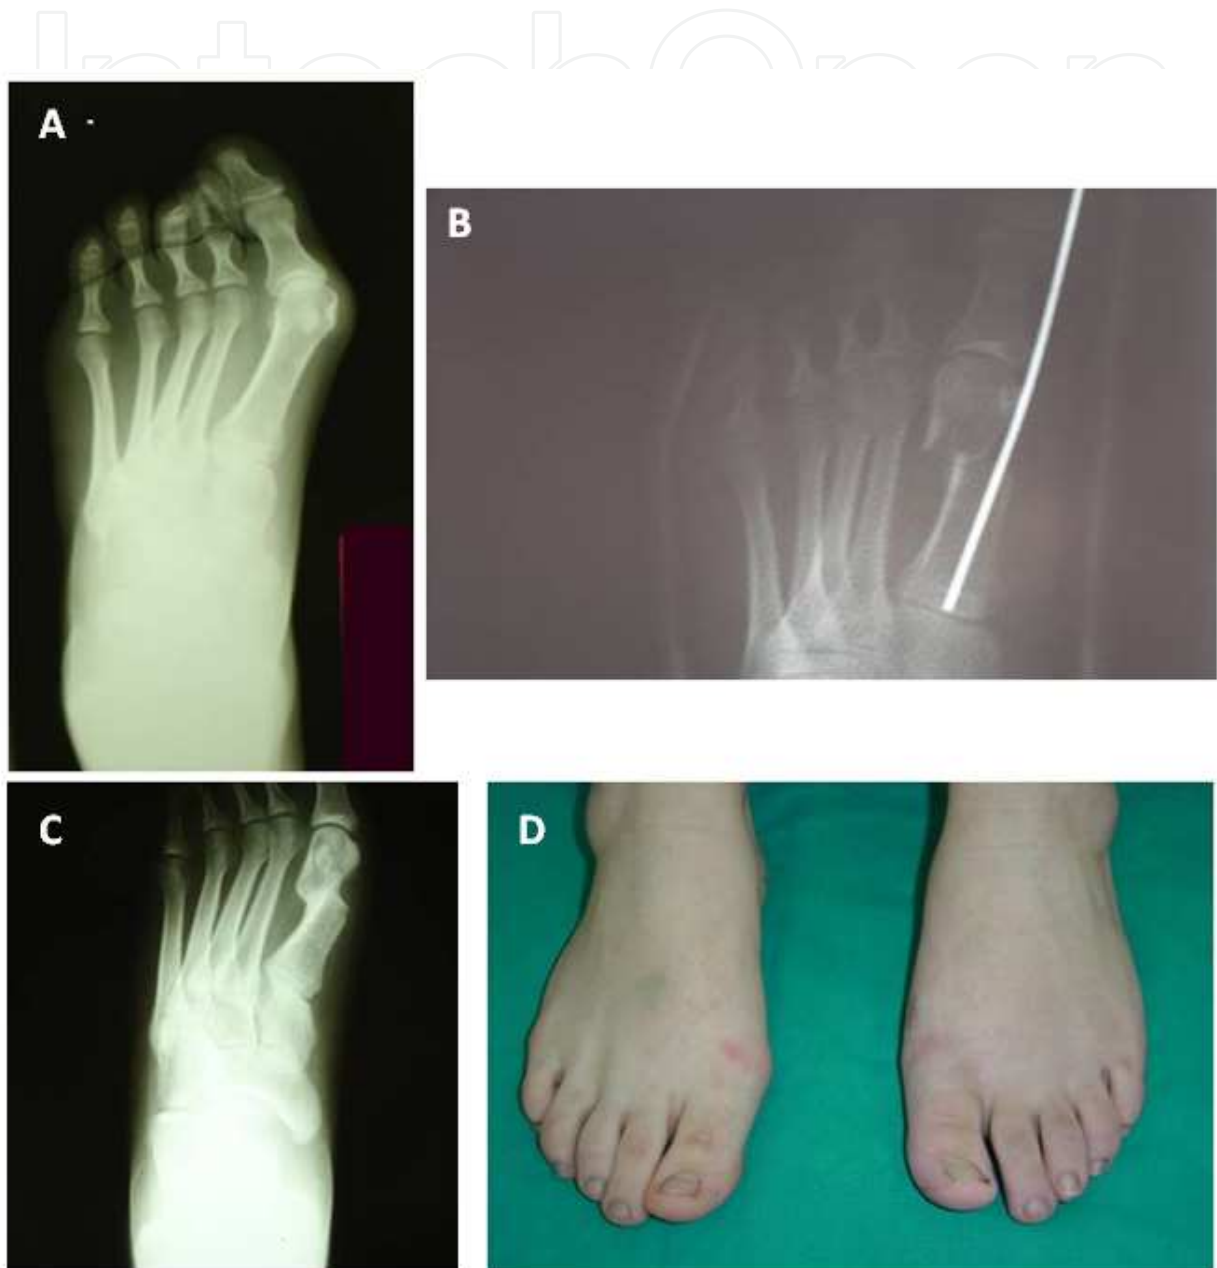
13 years old female with hallux valgus deformity of the left foot. The patient had been treated for flatfoot 2 years before. A, preoperative X-ray; B, Postoperative X-ray; C -D, X-ray and Clinical Control after 1 year.
